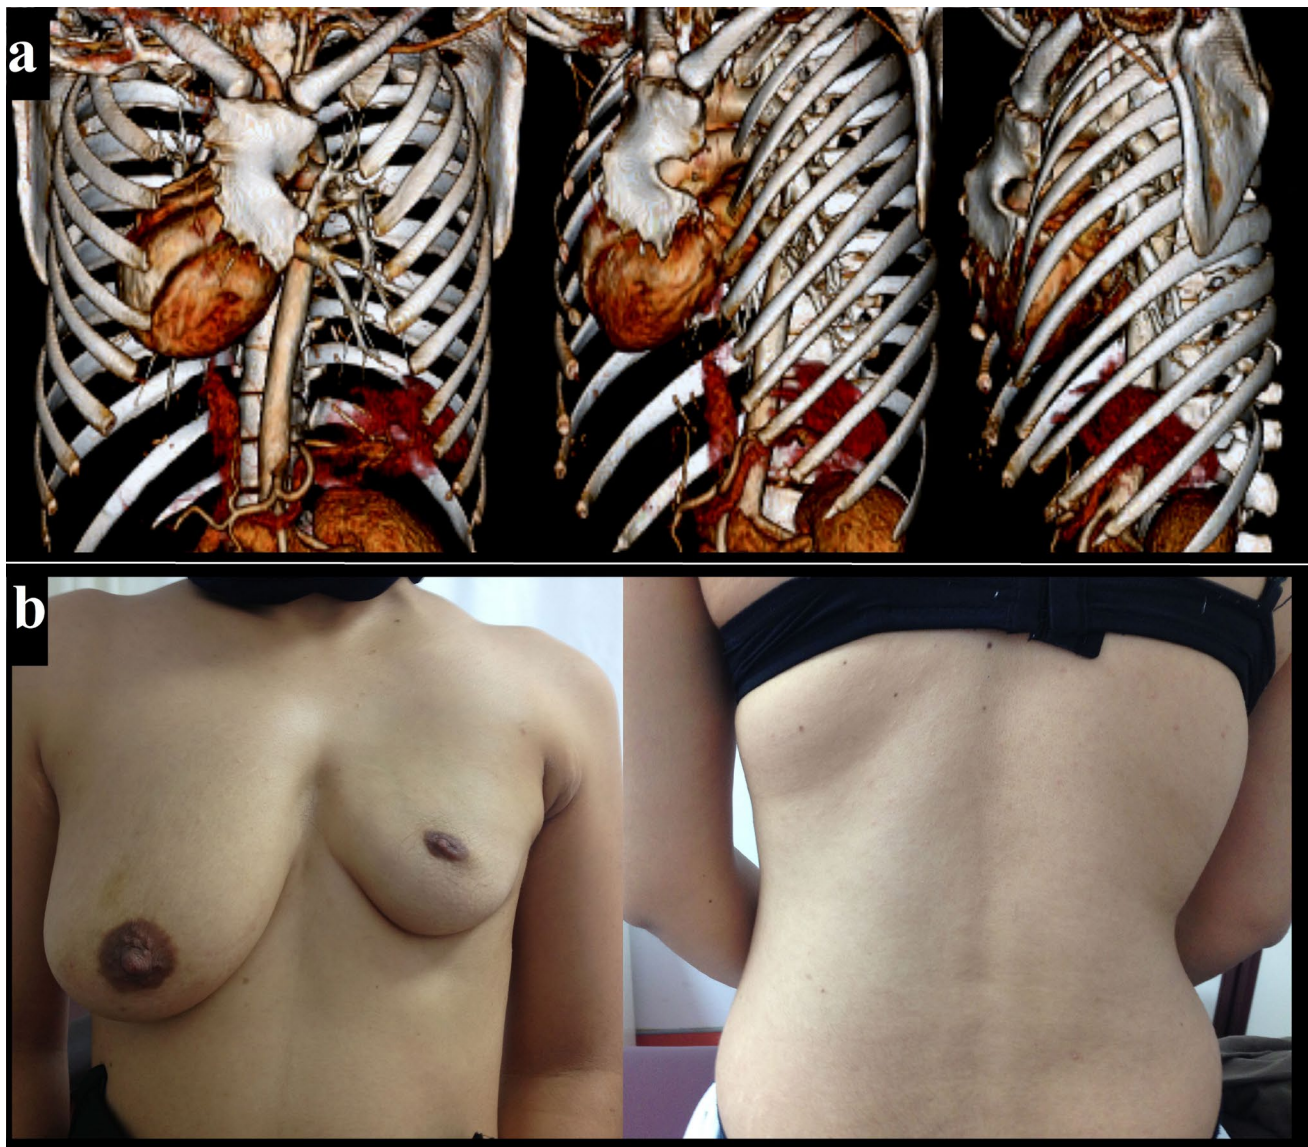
a) 3D-volume-rendered computed tomography images demonstrating pectus excavatum deformity and dextrocardia due to malformation of the sternum and costal cartilage on the left chest wall. b) Photos of the case show hypoplasia of the left breast and absence of the plica axillaris anterior, due to hypoplasia of pectoralis major muscle and hypoplasia of subcutaneous adipose tissue. The papillae mammae and areola mammae are hypoplastic and superiorly sited.
